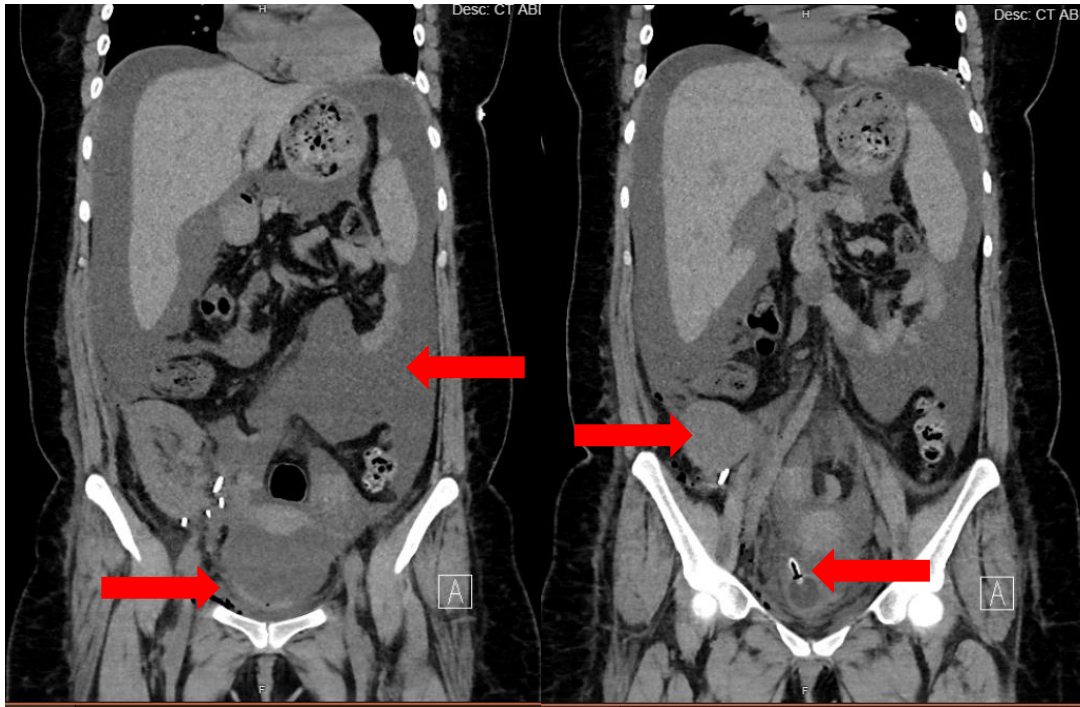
Coronal CT scans show ascites in the peritoneum, lack of hydronephrosis in transplant kidney, decompressed bladder, and urinary catheter.
